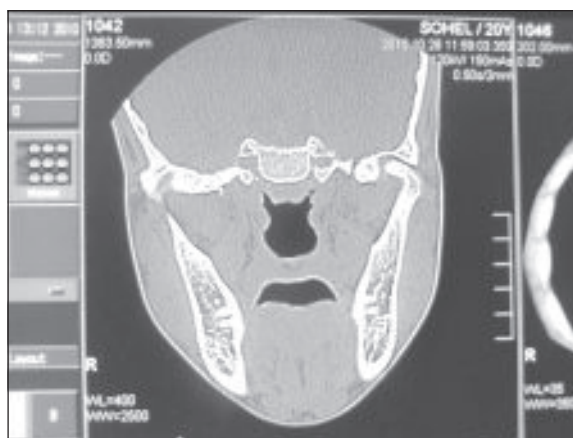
CT scan of paranasal sinuses - agenesis of sphenoid sinuses.
